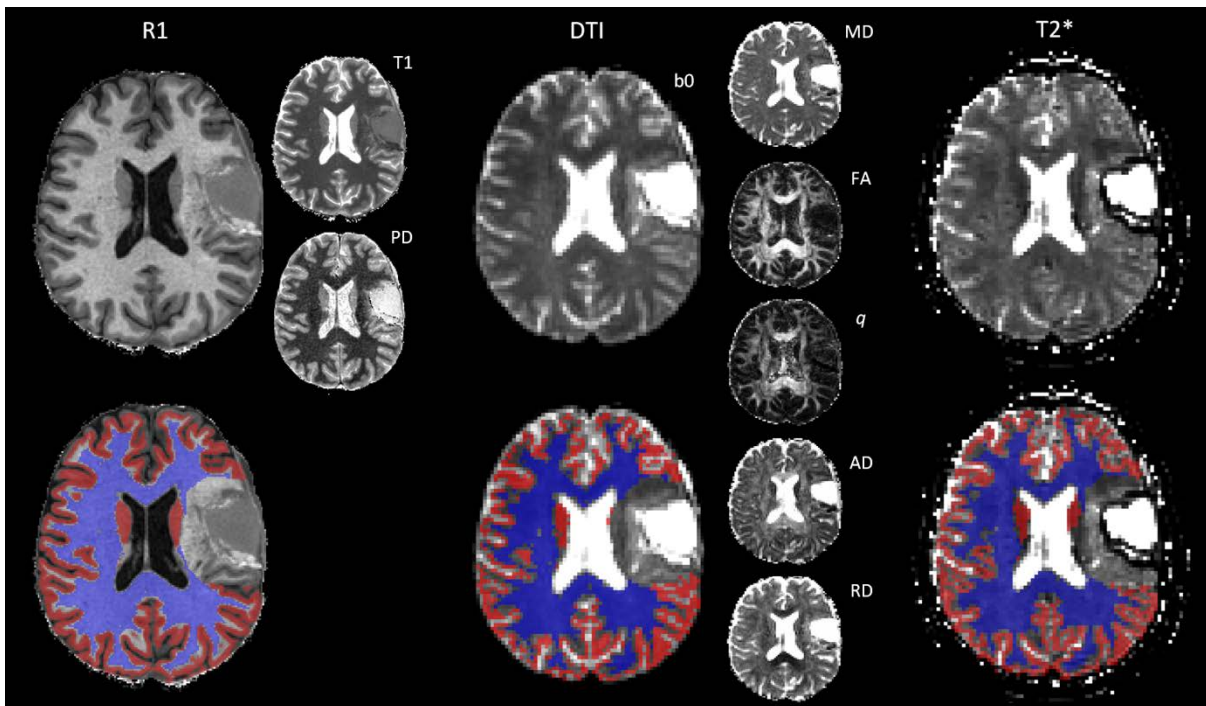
Overview of the multiparametric MR images of a patient (#9) with a resected grade III anaplastic astrocytoma before the start of radiotherapy and adjuvant chemotherapy [PCV: consisting of procarbazine, lomustine (CCNU) and vincristine]. GM and WM masks were obtained by SPM12 segmentation of the T1 map. The GM (red) and WM masks (blue) were coregistered to the DTI b0 image and T2\* map using a rigid body transformation and nearest neighbour interpolation. A subsequent probability threshold of 0.95 was chosen to binarize the GM and WM maps. Abnormal tissue was masked out prior to segmentation.
